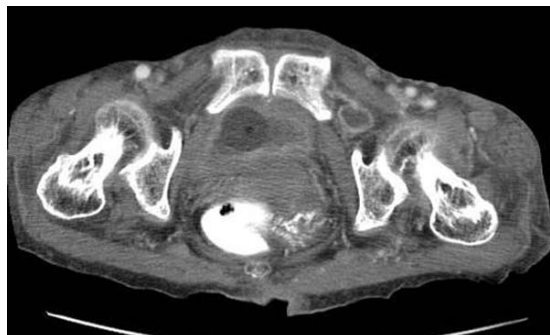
Case 1. Axial CT image of the pelvis shows a left obturator hernia.
